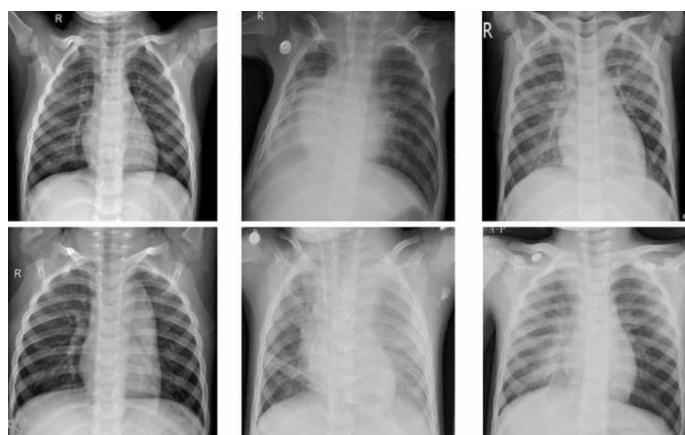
Classifies Pneumonia on Chest X-Ray*
